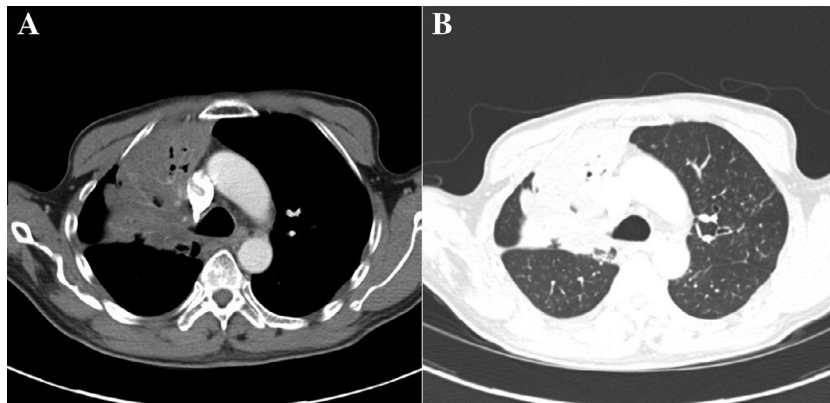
(A) Axial contrast-enhanced computed tomography (CT) demonstrates obliteration of the right upper lobe with ‘drowned lung’ due to atelectasis and bronchial tumor obstruction of the bronchus, mediastinal window, and (B) lung window.
